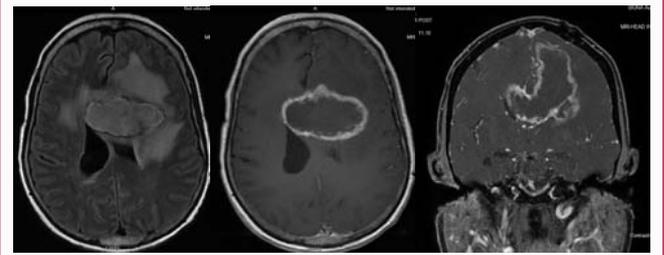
MRI dated 12/2/2019 demonstrating 6.4 × 4.4 × 6.7 cm (transverse × anteroposterior × craniocaudal) lesion. Sequences are (from left-to-right) axial T2 FLAIR, axial T1 post-contrast, coronal T1 post-contrast.
